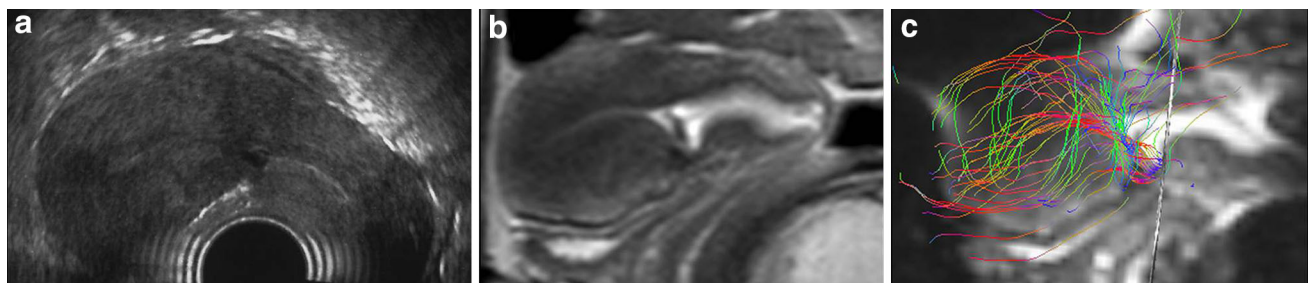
39-year-old woman with double caesarean delivery a TVUS image of caesarean scar classified as linear. b Para-sagittal T2 Ssh-TSE MR image of the same scar classified as retracting c 3T-MR-DTI
